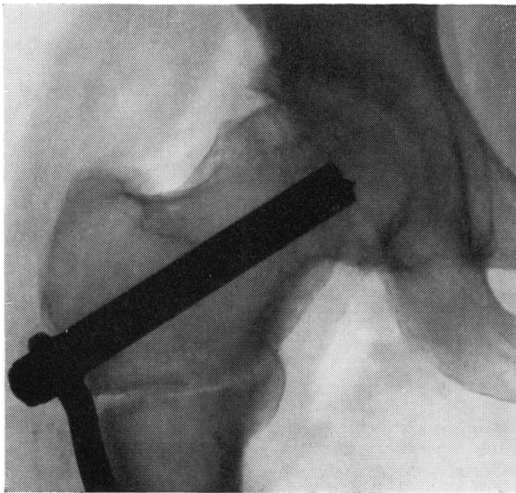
A radiograph taken after an experimental osteotomy intended to eliminate displacement (see text). The narrow gap left by a Gigli saw persists*
